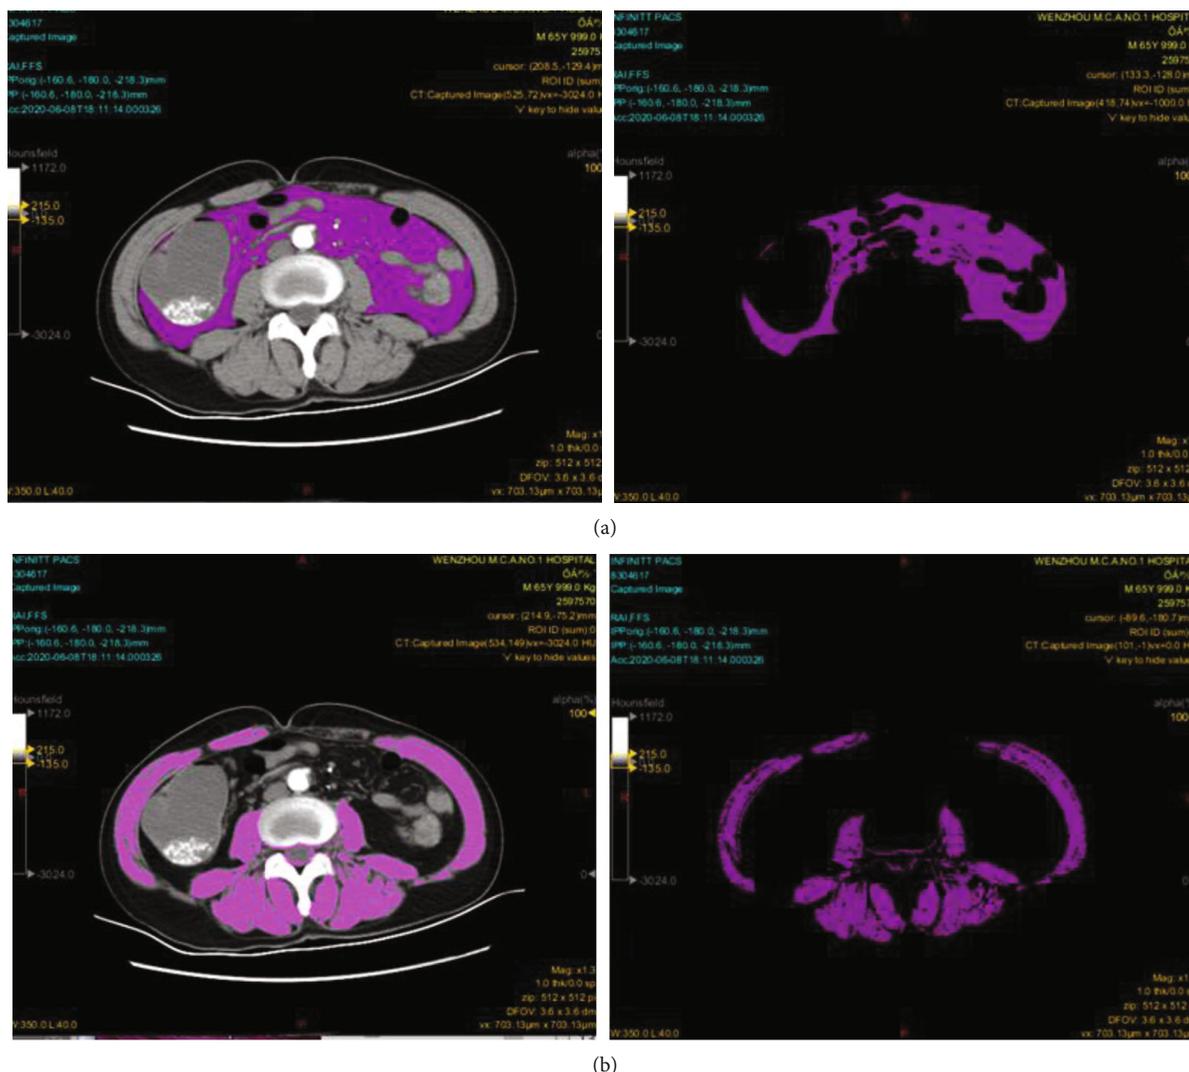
Example of a computed tomography (CT) scan with the area-based, densitometric quantification of adipose tissue (threshold:  $-190$  to  $-30$  HU) measured at spinal level L3/4: regions of interest (ROI) containing visceral fat area (VAT) (a) and an example of the densitometric quantification of muscle area (SM), dorsal and psoas muscles (threshold:  $40$  to  $100$  HU) (b).
